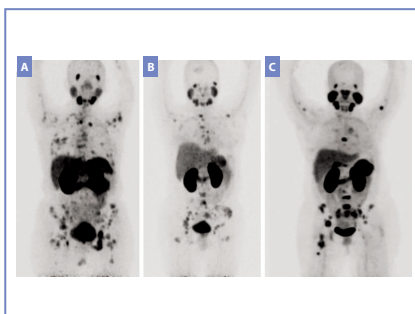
A. Maximal intensity projection (MIP) PET with [^{68}Ga]Ga-PSMA-11 in patient with triple negative (TPN) BC showed normal biodistribution and primary tumour site in right breast, multiple bone and lymph-node metastases. B. MIP in patient with luminal-B HER2 positive BC showed multiple bone metastases with faint uptake in primary site in the left breast. C. MIP in patient with Her-2 overexpression BC showed multiple bone metastases with faint uptake in primary site in the right breast. Image taken from [6].
